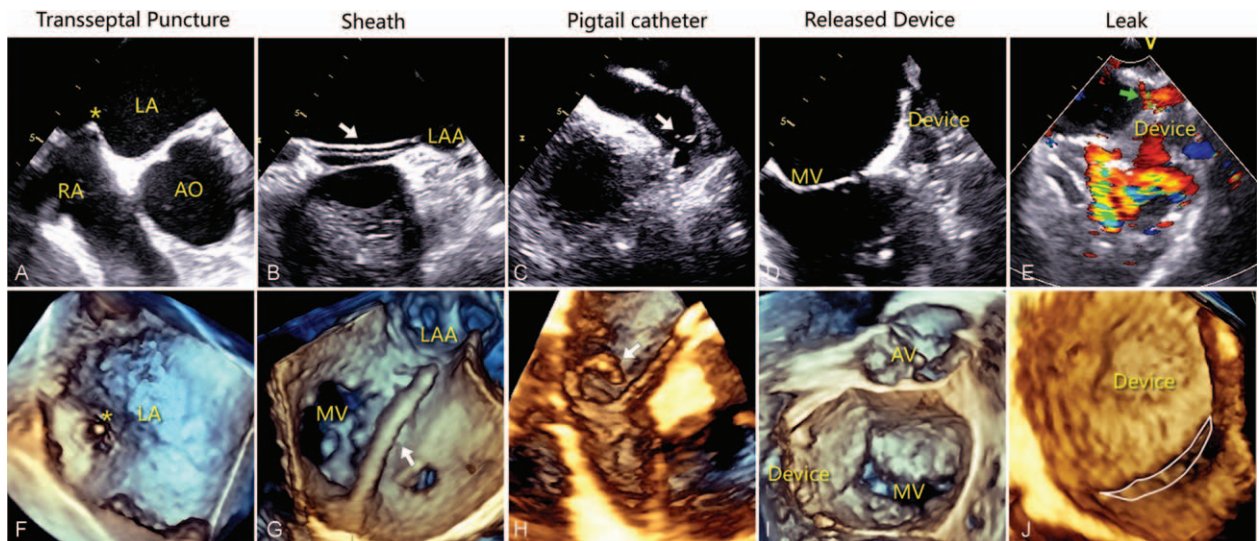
LAA closure procedures under the guidance of 2D TEE and RT 3D TEE. (A–E) The images of interatrial septal puncture position, sheath, pigtail catheter, release of device, and leak under the 2D TEE. (F–J) Image of interatrial septal puncture position, sheath, pigtail catheter, release of device, and leak under the 3D TEE. A “tent-like” sign could be seen when the puncture sheaths protruded the septum under the 3D TEE (F). The “en-face” view of the LAA ostium was displayed by RT 3D TEE (G), which identified the access of sheaths toward one of the ostium in a double-lobe LAA. 3D TEE is sensitive for the detection of the peri-device leakage which is featured by displaying the leakage area (J), while only a width of the shunt was observed for the per-device leakage in 2D TEE (E). 2D TEE = two-dimensional transesophageal echocardiography, 3D TEE = real-time three-dimensional transesophageal echocardiography, LAA = left atrial appendage.
